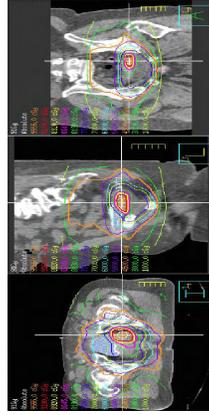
IMRT Plan analysis. Color-coded isodose threshold lines are superimposed over the planning CT images.
